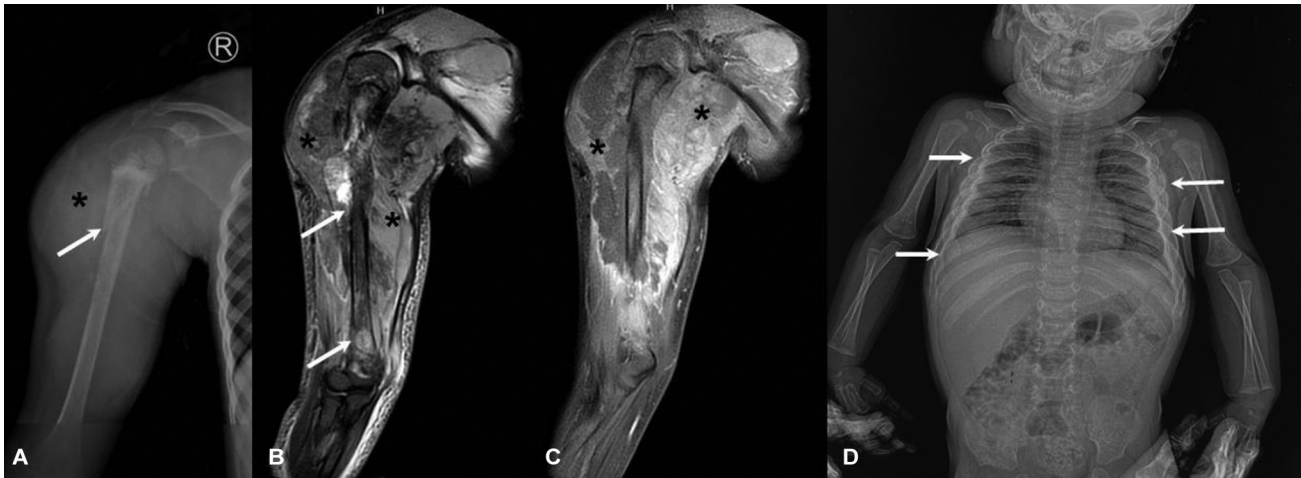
Differential diagnoses: (A–C) Ewing’s sarcoma in a 10-year-old with right arm swelling. Frontal radiograph demonstrates an ill-defined lytic lesion in right proximal humeral metadiaphysis with wide zone of transition, pathological fracture (arrow, A), and a disproportionate soft tissue component (asterisk, A). Coronal T2 fat-suppressed and postcontrast images assist in delineating the widespread marrow involvement, which spans the entire humerus (arrows, B), with physeal involvement and a large heterogeneous soft tissue component (asterisks, B and C). (D) Caffey’s disease in an infant. Infantogram (D) shows expansion and hyperostosis in lateral ends of bilateral ribs (arrows, D).
